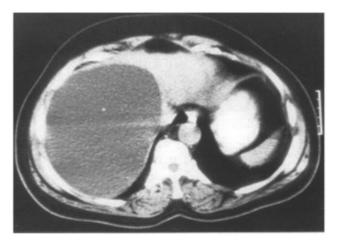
CT scan of a right lobe liver cyst.
